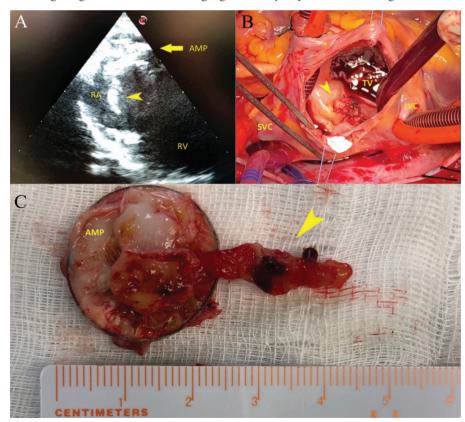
Echocardiographic and operative images. A) Pre-operative transesophageal echocardiographic findings, in TransGastric RV inflow, of infective endocarditis (arrowheads) adherent to the body of the Amplatzer (AMP) projecting into the right atrium. It commits the tricuspid valve in systolic movement without adhesion to it. RA, Right Atrium; RV, Right Ventricle. B) Surgical view of the endocarditis (arrowheads) from a right atrium approach in bicaval cannulation. SVC, Superior Vena Cava; ICV, Inferior Vena Cava; TV, Tricuspid Valve. C) Surgical sample of endocarditis (arrowheads) adherent to the removed Amplatzer (AMP).
